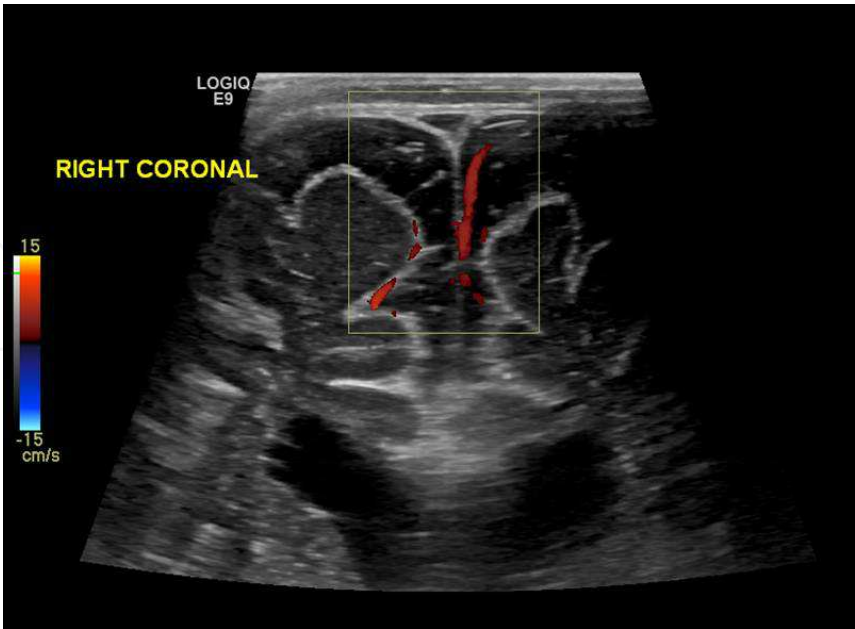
High resolution linear image demonstrating prominent extra axial CSF spaces. Doppler interrogation demonstrates a vessel crossing the space, confirming subarachnoid fluid rather than subdural.
